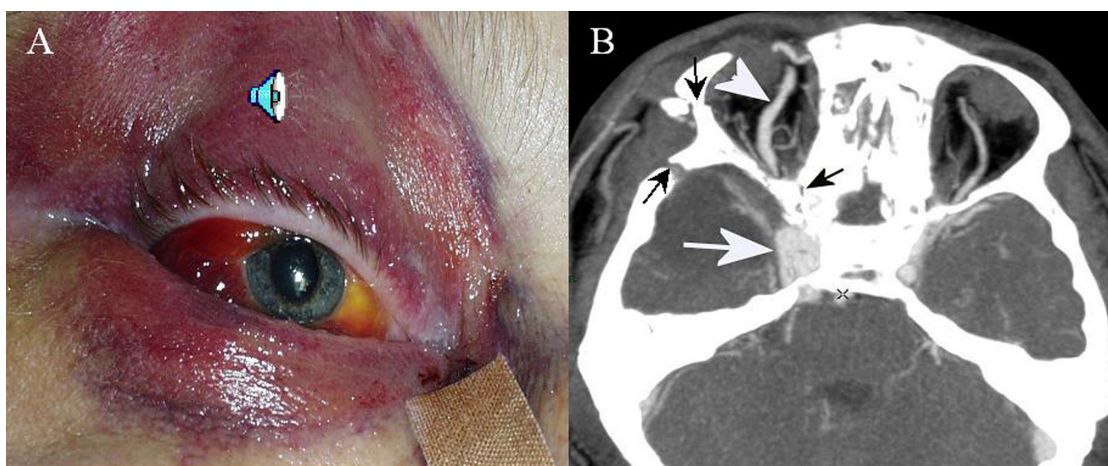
A. Periorbital hematoma, complete ophthalmoplegia and loss of pupillary light reflex. Audible bruit over the eyeball (audio). B. Head CT scan with enlarged right cavernous sinus. Click on image for periorbital noise audio (<http://repositories.cdlib.org/cgi/viewcontent.cgi?filename=0&article=1291&context=uciem/westjem&type=additional>).
